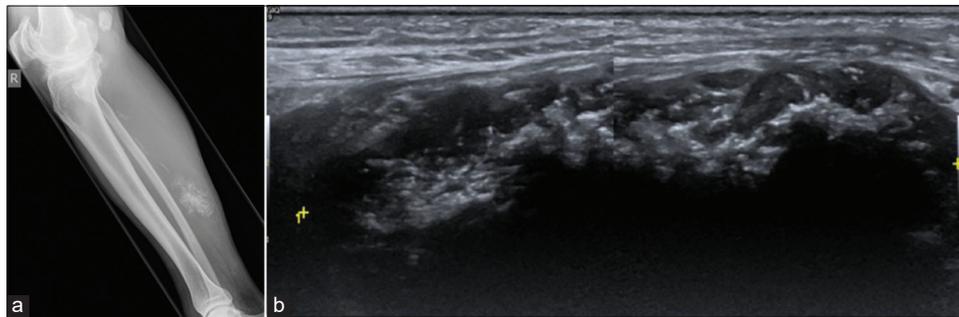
(a) Lateral radiograph of the patient in confirming calcification in the mass in the posterior aspect of the calf. (b) Extended field of view longitudinal ultrasound of the right calf demonstrates a hypoechoic mass with intralesional calcification, located within the soleus muscle.
